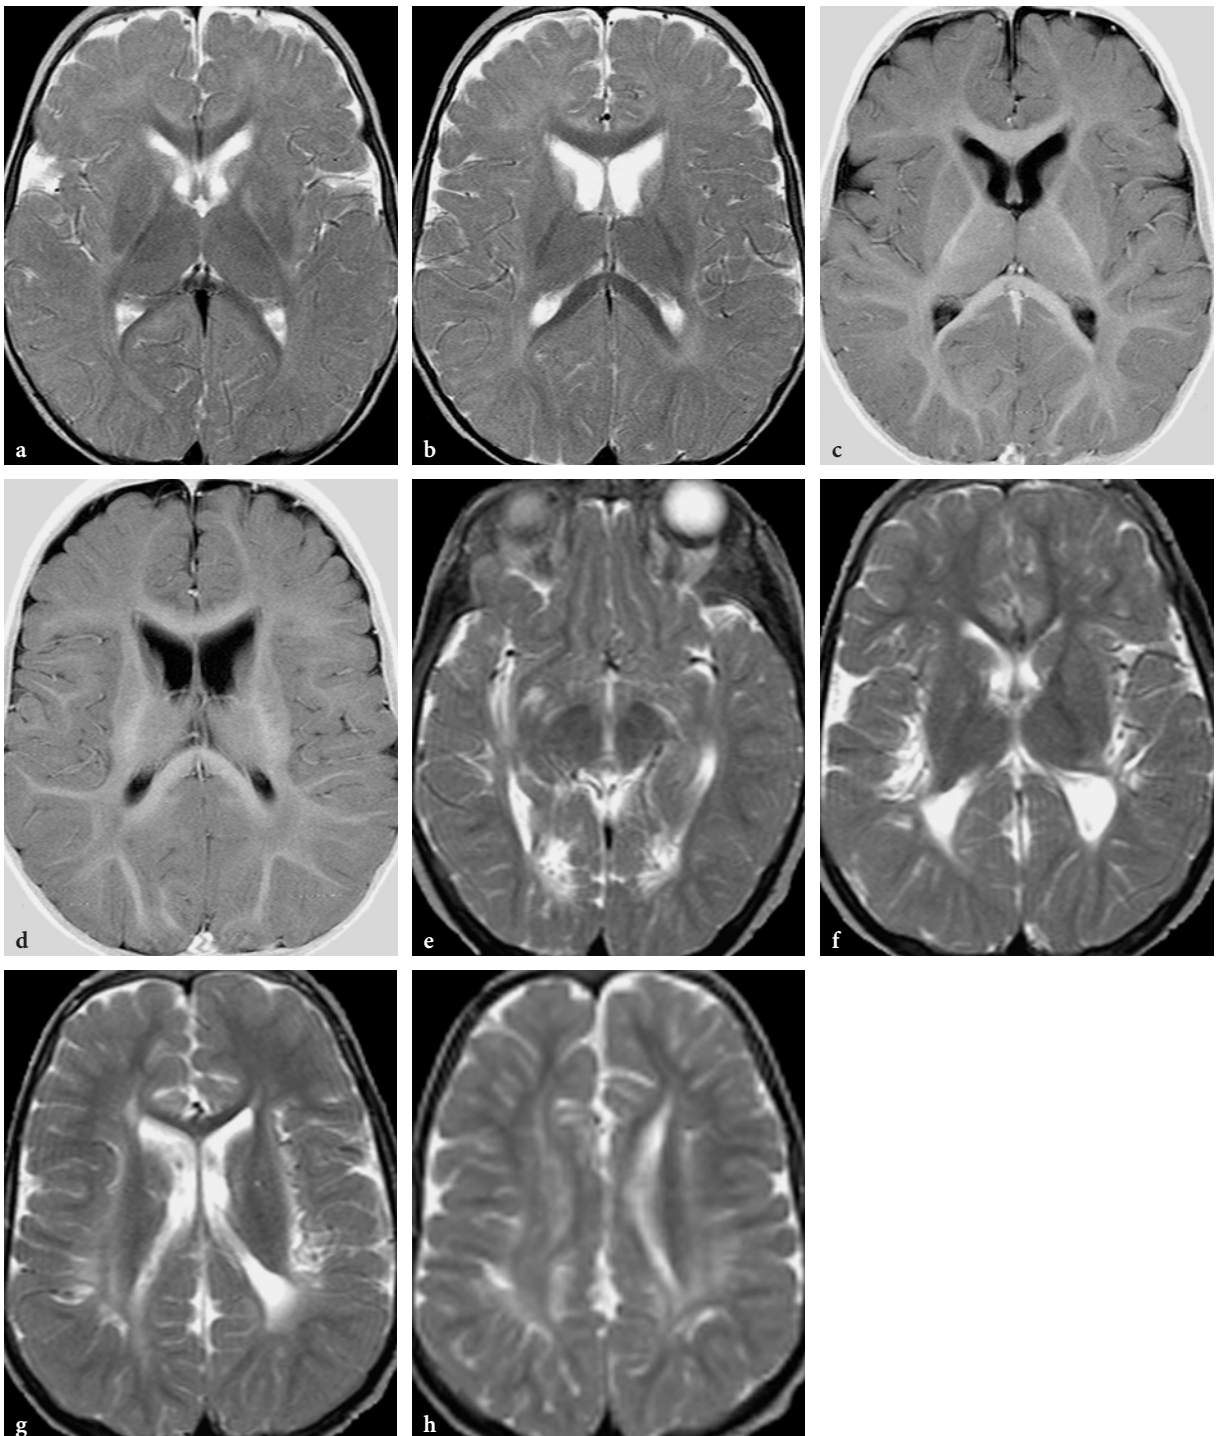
MR imaging findings in the chronic stage of urea cycle defects. a–d Axial T2-weighted fast spin-echo (a, b) and T1-weighted inversion recovery (c, d) images in a 1-year-old female patient with argininosuccinic aciduria. Subtle signal abnormalities are seen within the globi pallidi and heads of the caudate nuclei. Diffuse hypomyelination with an element of delayed myelination affecting mainly peripheral white matter structures. e–h Axial T2-weighted fast spin-echo images in a 5-year-old male patient with citrullinemia. Extensive, predominantly subcortical white matter lesions associated with atrophy. In the subsular and occipital regions, cortical structures appear to be involved. Subtle signal changes are suggested within the heads of the caudate nuclei, perhaps even within the globus pallidus on the right side. Note severe atrophy of the splenium of the corpus callosum (f, g)
